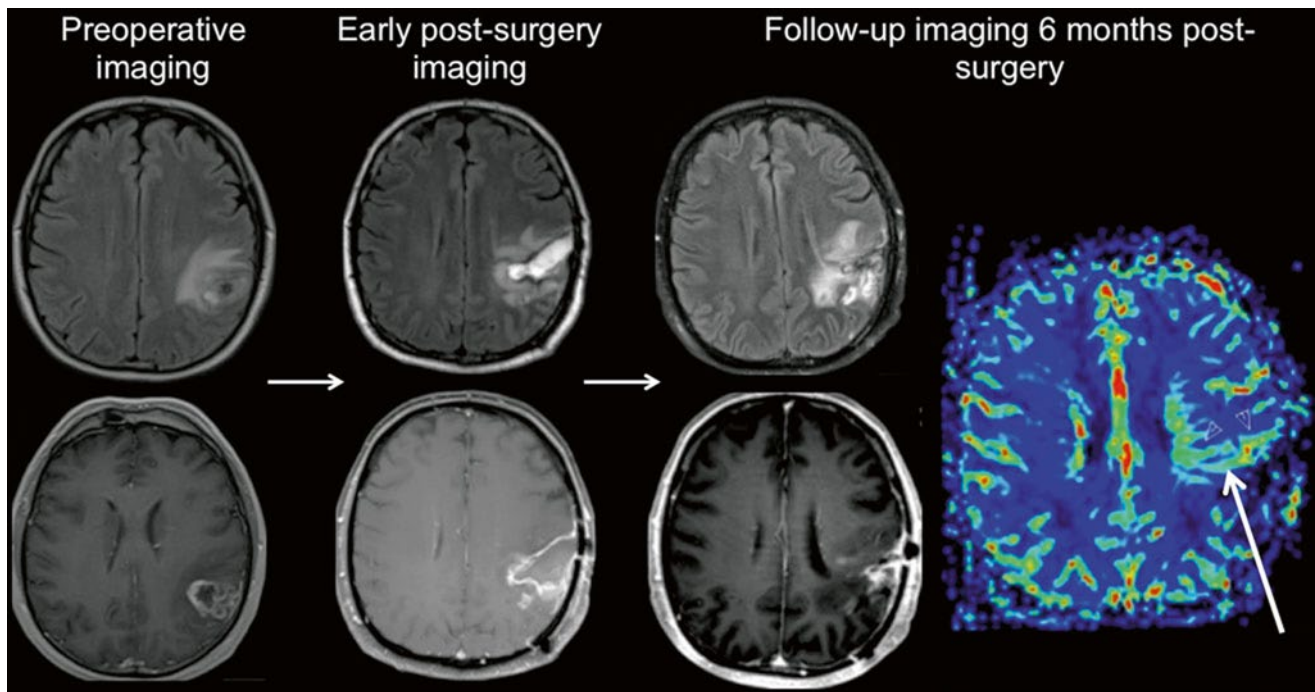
Imaging follow-up of a glioblastoma patient. Preoperative imaging (axial FLAIR and post-Gd T1w) shows a partially necrotic tumor with infiltrating borders and contrast enhancement. Early post-surgery imaging (axial FLAIR and post-Gd T1w) shows persisting T2 lesion and no enhancement (T1w hyperintensities correspond to blood
